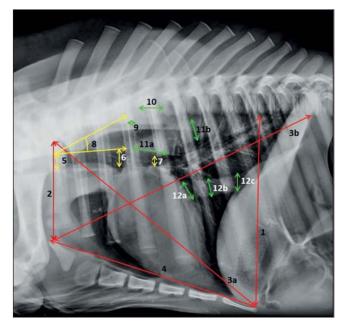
Radiograph of the chest of a calf showing thoracic cavity, airway and great vessels measurements; the thoracic depth (1), Thoracic inlet diameter (2), diagonal size of the thorax (3a and b), length of the sternum (4), the trachea diameter at thoracic inlet (5), the maximum trachea diameter (6), the carina (7) and the trachea inclination angle (8), the diameter of 4th rib (9), the length of vertebra above carina (10), the diameter of Aorta at base (11a), diameter of Aorta in alignment with CVC (11b), the diameter of CVC at base (12a), diameter of CVC in alignment with Aorta (12b), diameter of CVC at diaphragm (12c).
